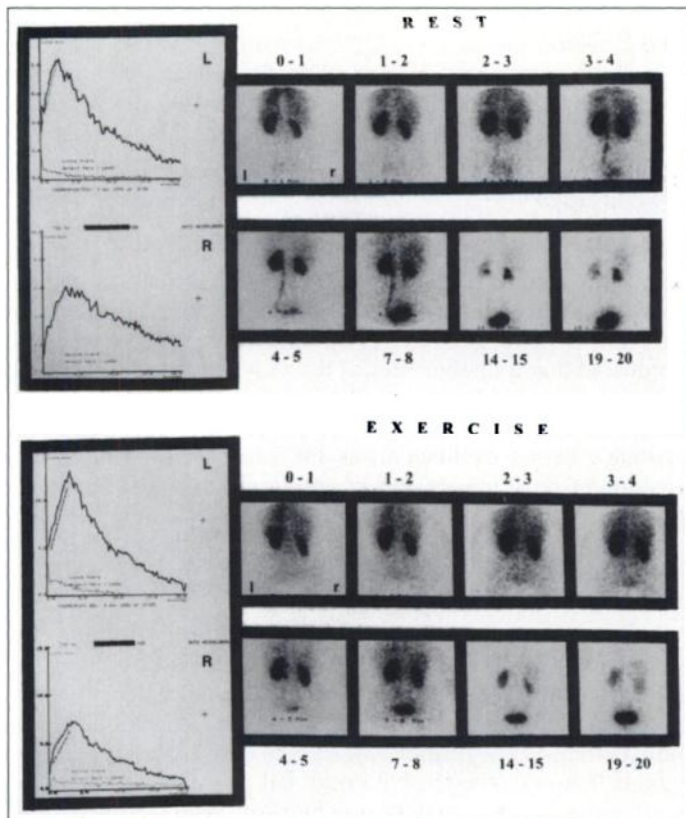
A 45-yr-old hypertensive man had a four drug regimen including a calcium antagonist,  $\beta$ -blocker, sympatholytic and diuretic drug at scintigraphy (BP = 170/120 mm Hg). Angiography = unilateral renal artery stenosis left. Note: reduced tracer uptake in the left kidney. Function left 36% (GFR 53 ml; ERPF 248 ml; FF 0.22). Exercise renography demonstrates bilateral tissue retention of the tracer, delayed excretion into the bladder and an accumulation renogram (GFR 16 ml; ERPF 171 ml; FF 0.09). It was concluded that both renovascular and essential hypertension were present.
